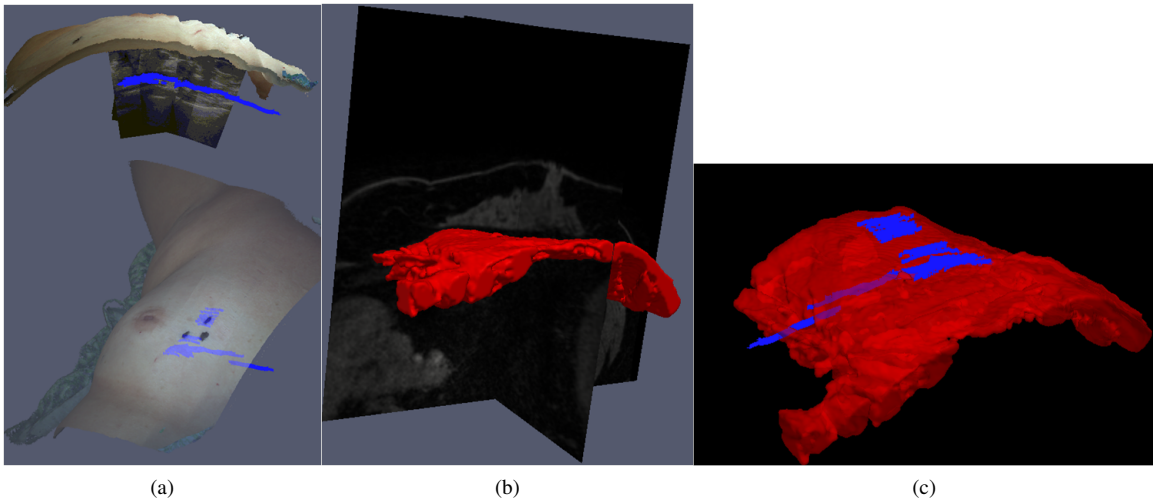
(a) Top: Ultrasound images of the chest wall with chest wall contours shown in blue rendered below the LRS in physical space. Bottom: transparent overlay of the LRS showing ultrasound contours of the chest wall in blue. (b) Segmentation of the preoperative chestwall from the MR image volume. (c) Rigid registration of the preoperative chestwall (red) to the intraoperative tracked ultrasound digitized chest wall contours (blue)
